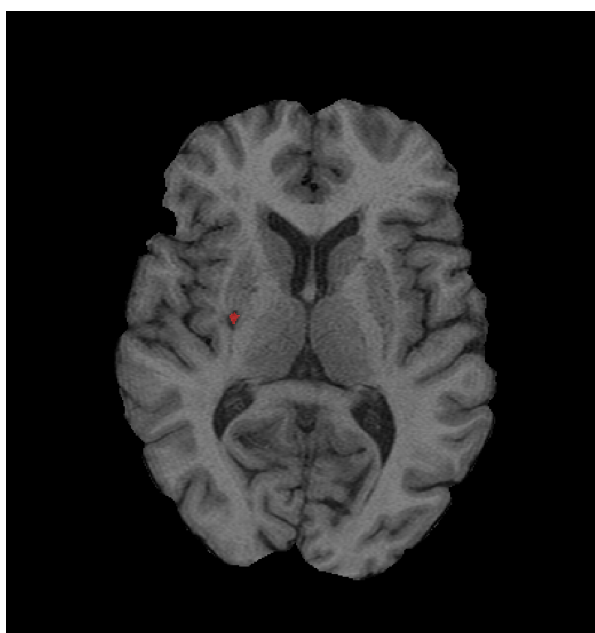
Lacunes occupy only a small amount of the pixels on an MRI image.
